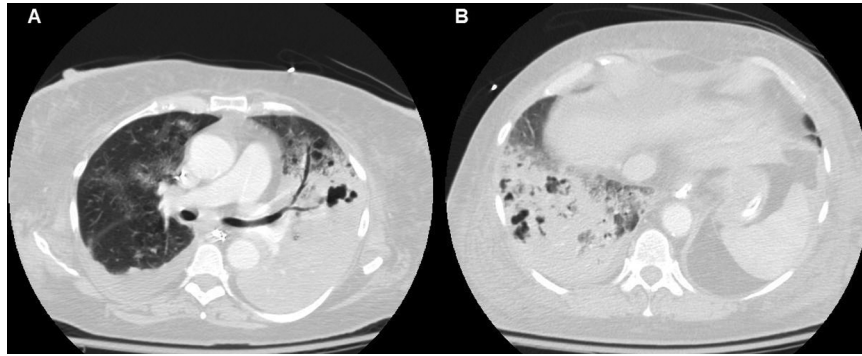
Chest computed tomogram with contrast obtained on day 4 of admission. A: The left lung has diffuse consolidation, air bronchograms, and areas of cavitation. There is a right-sided pleural effusion. B: The right lung base has consolidation and areas of cavitation.
